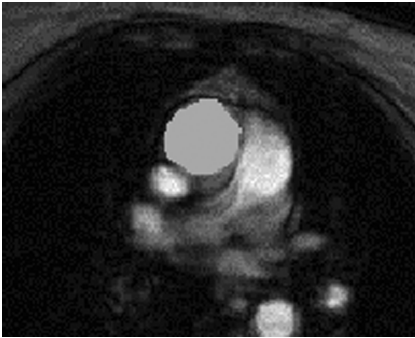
The segmentation of blood vessel shown in the magnitude and phase MR images of human cardiac cavity shown in Figure 14.2 using the wavelet-based frequency localization features.
